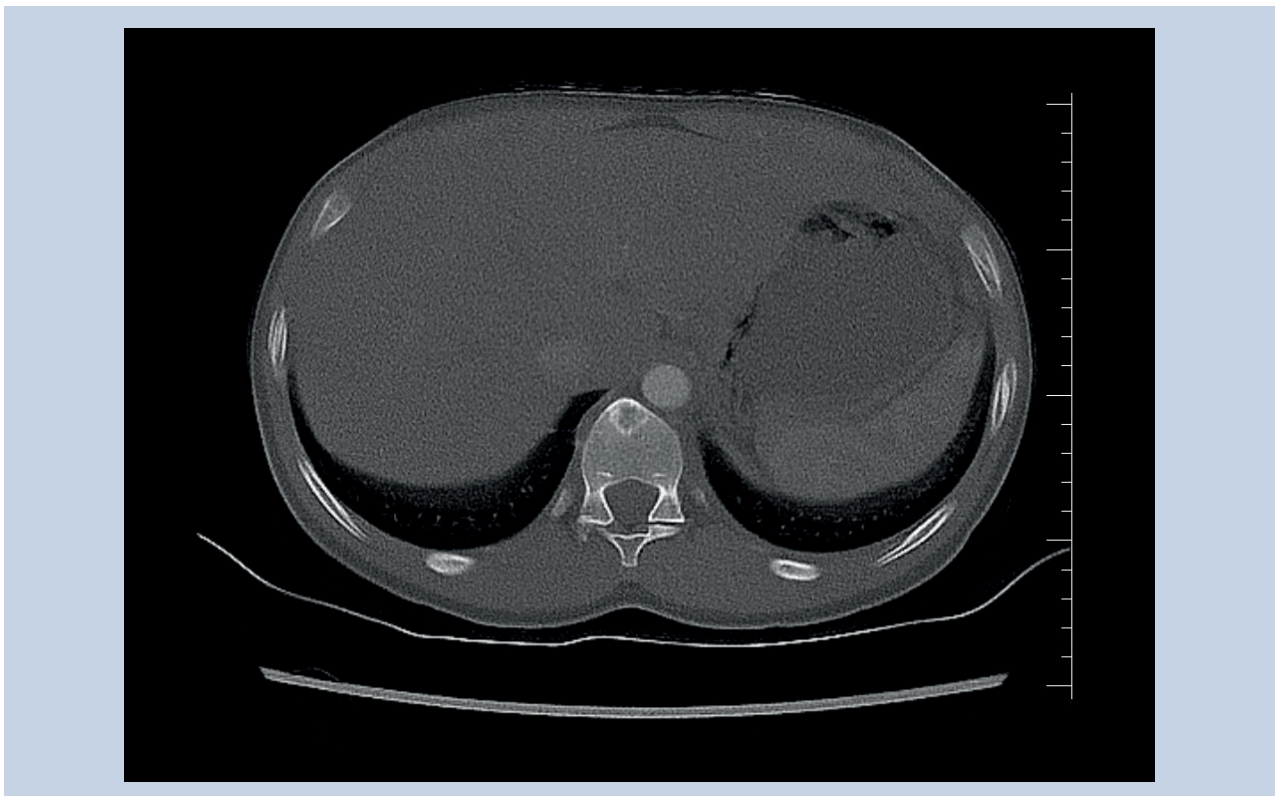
Computed tomography showing a sclerotic defect in the anterior portion of the Th12 vertebral body
